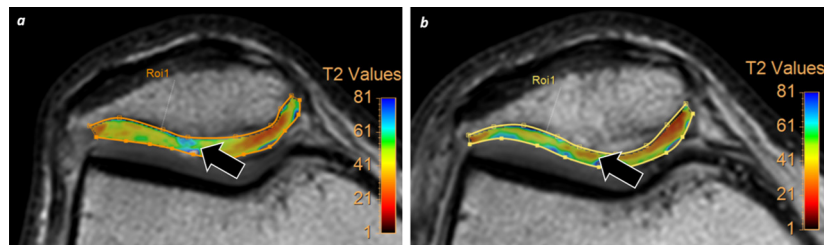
Treatment monitoring. A 46-year-old male with knee pain. (a) First study was performed on January 2018 whereas a focal area of increase of T2 relaxation values was identified at lateral aspect of articular surface of patella (white arrow) on T2-mapping sequences consistent with chondromalacia. Patient undergone surgery (chondrocyte graft) and a new MRI was performed on March 2019. (b) This new study shows decrease of T2 values at surgical area (white arrow) which suggest presence of new hyaline cartilage.
